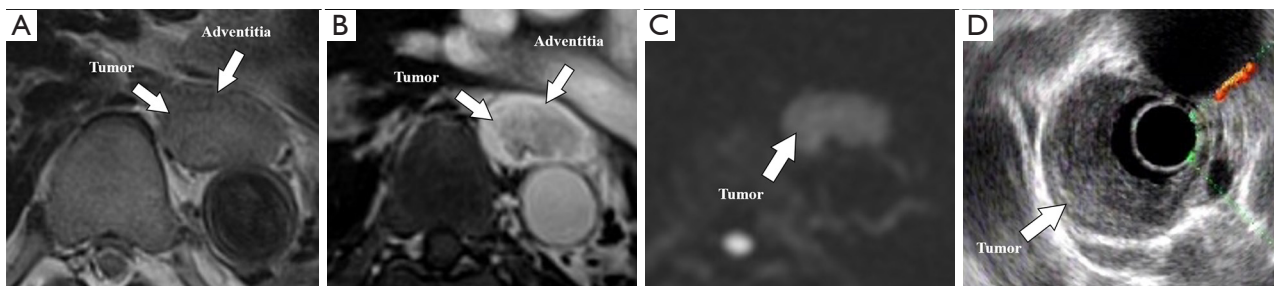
A 70-year-old male patient with T3 esophageal cancer: (A) T2WI BLADE, (B) enhanced T1WI StarVIBE, (C) DWI ($b = 800$), and (D) EUS. The tumor is confined to the adventitia. T2WI, T2-weighted imaging; T1WI, T1-weighted imaging; StarVIBE, stack-of-stars volume interpolated breath-hold examination; DWI, diffusion-weighted imaging; EUS, endoscopic ultrasound.
